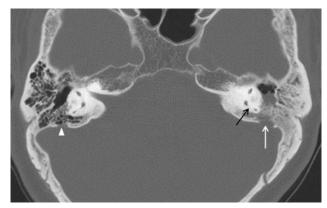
Subject 4. Axial CT scan at the level of the common crus (*black arrow*) shows a large bone defect caused by presumed AG (*white arrow*), located at the lateral third of the posterior wall of the left temporal bone. There also is a loss of the posterior wall of the mastoid air cells, which are opacified with fluid. This 41-year-old man presented with CSF otorrhea and recurrent septic meningitis. He underwent dural repair via intact canal wall mastoidectomy. Also noted is a small bone defect caused by presumed AG (*arrowhead*), located at the lateral third of the posterior wall of right temporal bone.
